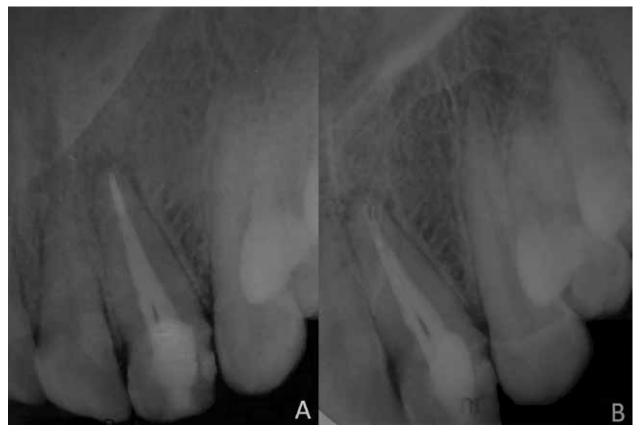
4a: Orthograde radiograph shows both canals superposed, creating an image of joined canals at the apical third. 4b. Distal angled radiograph shows the real orientation of buccal and palatal root canals; both of them with independent foramina.
